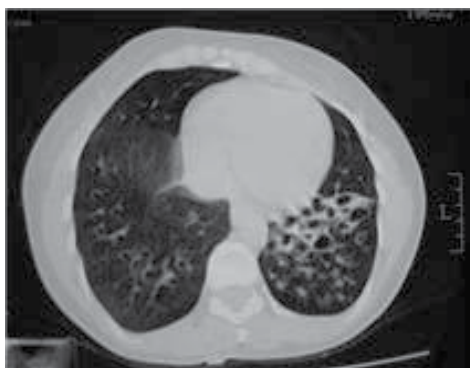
Chest CT scan showing bilateral cystic bronchiectasis in the lower lobes.
